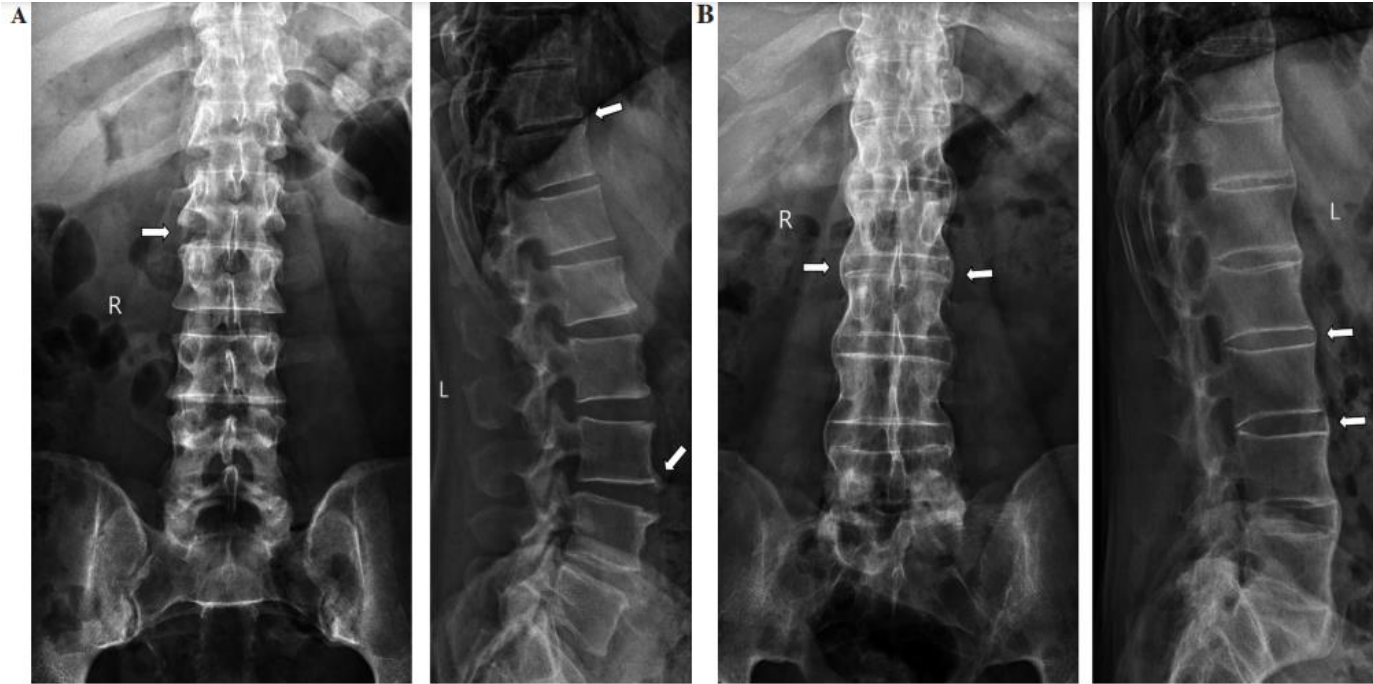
Example of conventional radiographs of the lumbar spine from a patient with psoriatic arthritis with axial involvement (PsA, Fig. A) and ankylosing spondylitis (AS, Fig. B). Overall, radiographic evidence of syndesmophytes is less common in PsA than in AS. Spinal disease in PsA is more frequently unilateral, the syndesmophytes show a larger volume, do not follow exactly the course of the anterior longitudinal ligament and do not appear in consecutive vertebrae, as compared to AS.
